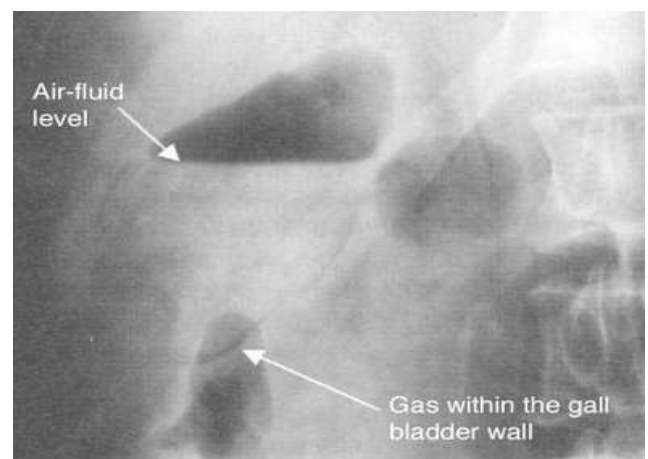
Plain radiographs showing emphysematous cholecystitis.
